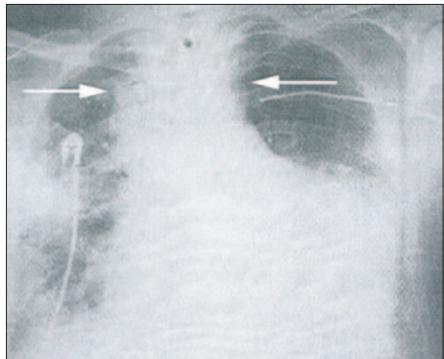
Chest radiograph showing a widened mediastinal configuration
